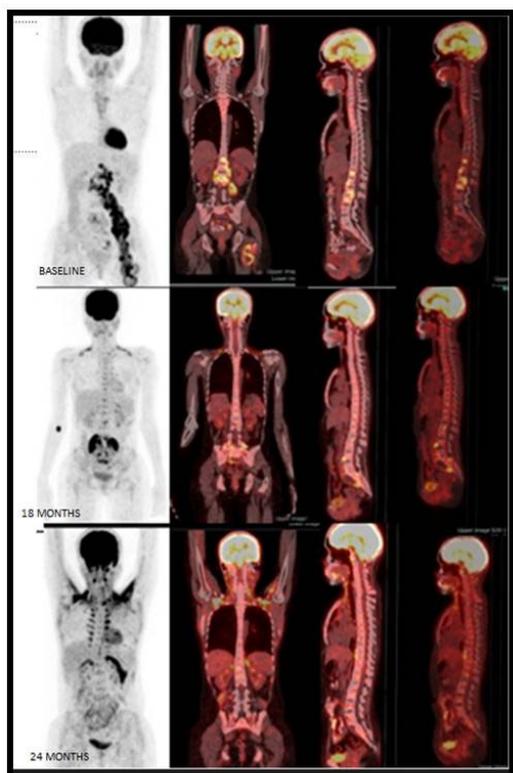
Baseline [^{18}F]FDG/PET/CT [MIP, fused coronal, sagittal, and sagittal bone window] images of 28-year-old lady with recently diagnosed spinal tuberculosis revealed hypermetabolic lytic sclerotic thoracic and lumbosacral lesions and left paravertebral soft tissue (abscess). 18-month images demonstrate FDG uptake in the vertebral lesions and the left paravertebral soft tissue-residual active disease. 24-month images showed no significant FDG concentration in the above mentioned lesions-healed status.
